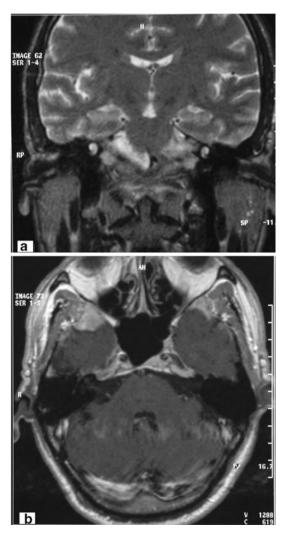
Coronal, T2 weighted MRI scan with gadolinium contrast and axial, T1 weighted MRI scan without contrast shows no cochlear pathology
